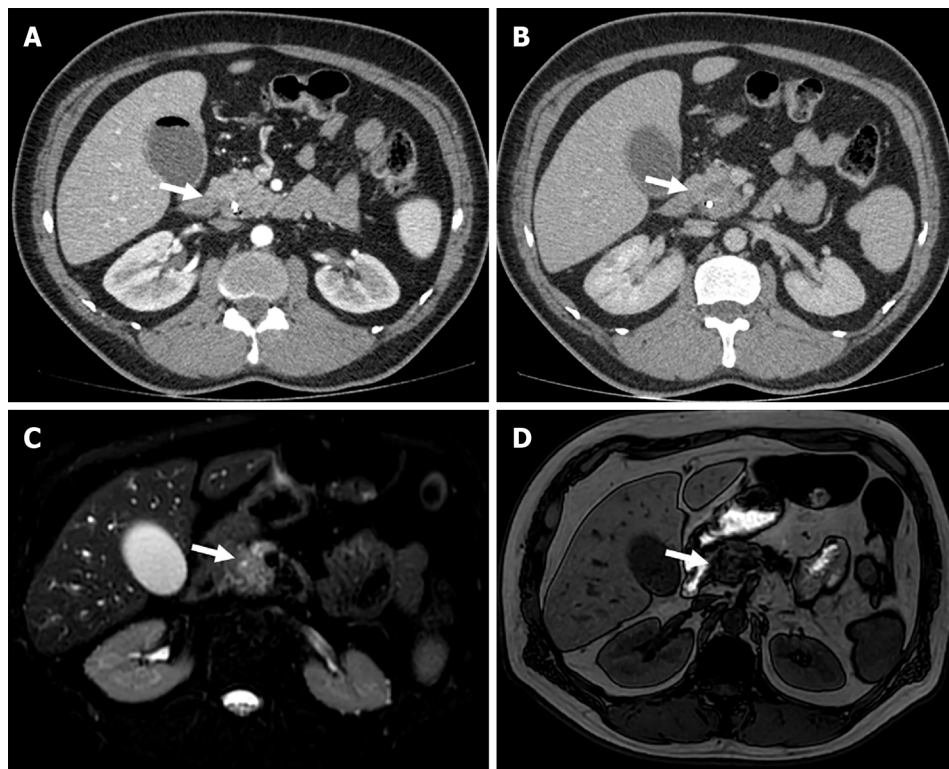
Pancreatic ductal adenocarcinoma in a 72-years-old man with obstructive jaundice. A: Axial contrast-enhanced computed tomography image shows a well-circumscribed exophytic tumor in the pancreatic head with heterogeneous enhancement in delayed arterial; B: Portovenous phase; C: Axial magnetic resonance fat suppression T2-weighted images image showing a mildly hyperdense irregular mass in the head of the pancreas; D: T1-weighted images with hypointense signal.
